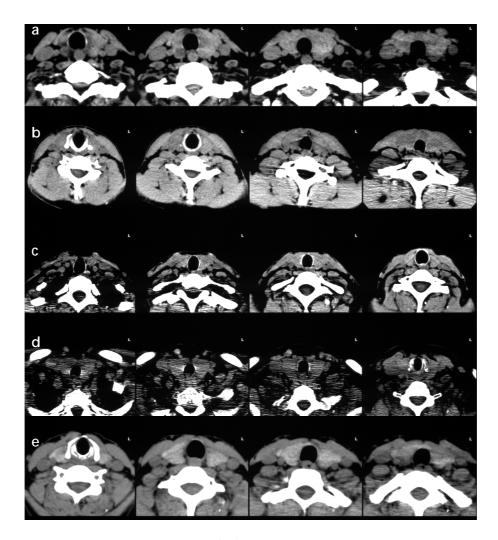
CT images of 5 patients (a-e), at the level of the thyroid gland. Four cross-sections with interslice gaps of approximately 1.5 cm are shown for each patient study.
